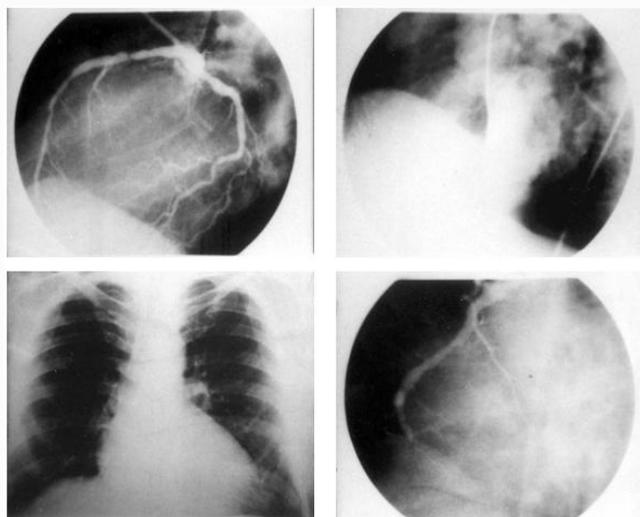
Left upper: Shows the proximal 80% narrowing of left anterior descending artery. Left upper: Shows the proximal 80% narrowing of left anterior descending artery. Right upper: Ventricular septal defect and the dextraposition of the aorta in the left ventriculography. Left lower: Chest X-ray shows cardiac enlargement. Right lower: Total occlusion of the right coronary artery after the acute marginal branch.
